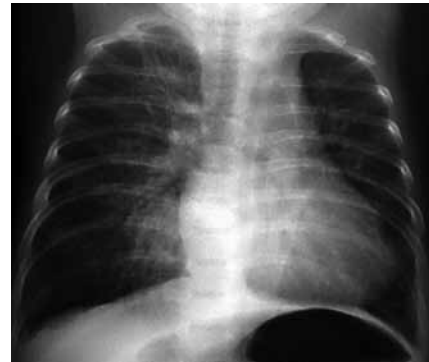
Preoperative radiography shows cardiomegaly.
